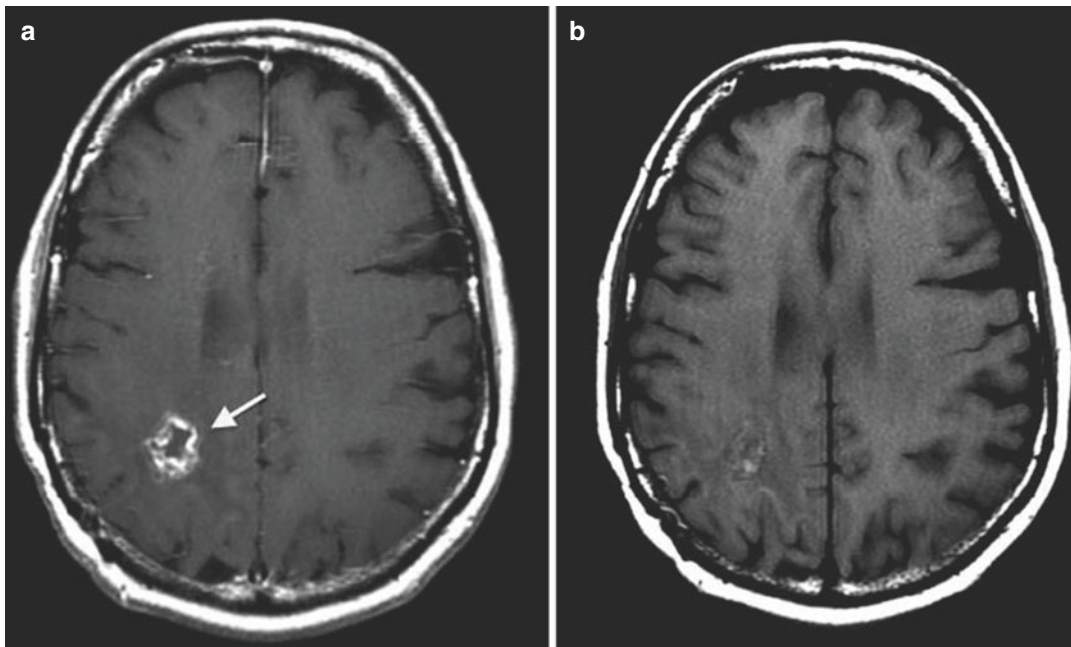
1-year follow-up gadolinium-enhanced MRI of patient in image Fig. 11.14. MRI was repeated every 3–4 months according to European Society for Medical Oncology (ESMO) clinical guidelines. There has been no evidence of disease progression for 1 year of follow-up.
